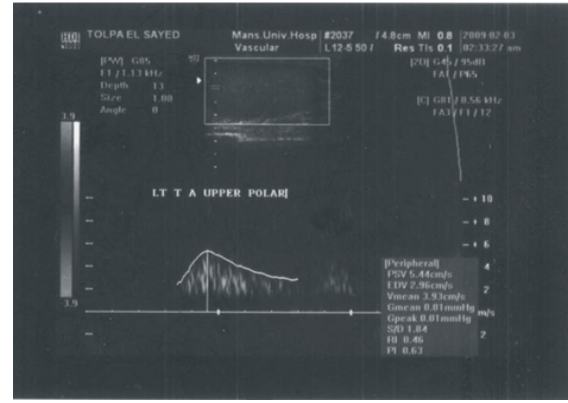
Doppler image of left testicular artery upper polar.
